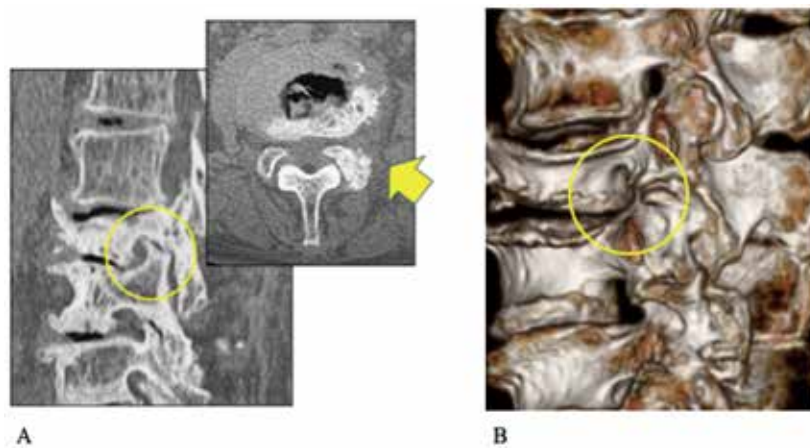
Preoperative computed tomography (CT) images. A : Multi-planar reconstructed sagittal CT image showing foraminal stenosis due to the superior articular process (SAP) of L4 (yellow circle) and an axial CT image showing sclerotic change and a bone spur on the left SAP of L4 (yellow arrow). B : Three-dimensional reconstructed CT image showing narrowing of the intervertebral foramen on the left at L3-L4.
